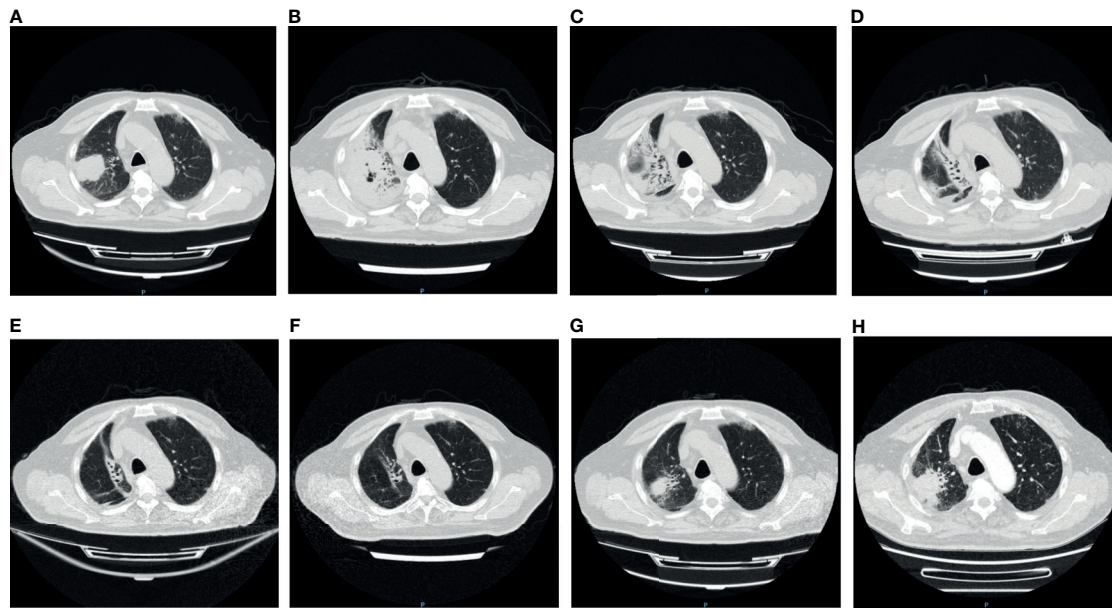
The variation of the tumor and inflammation in Chest CT. (A) Pre-immunotherapy: the tumor was seen in the right lung; (B) 2 weeks after immunotherapy: patchy shadows appeared around the tumor and air holes occurred in the tumor; (C) 4 weeks after immunotherapy: more air holes developed in the tumor and patchy shadows; (D) 5 weeks after immunotherapy: the tumor and patchy shadows were dissipating; (E, F) 8/12 weeks after immunotherapy: the tumor disappeared, with several linear shadows leaving; (G) 16 weeks after immunotherapy: the tumor reappeared in original site; (H) 18 weeks after immunotherapy: the tumor enlarged.
